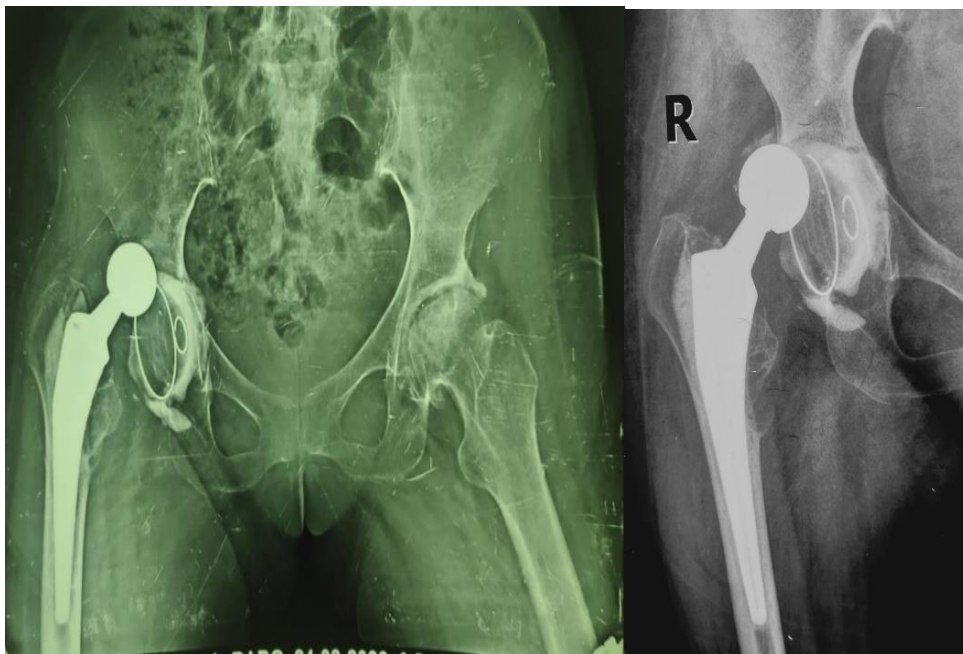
pre-operative x-ray
